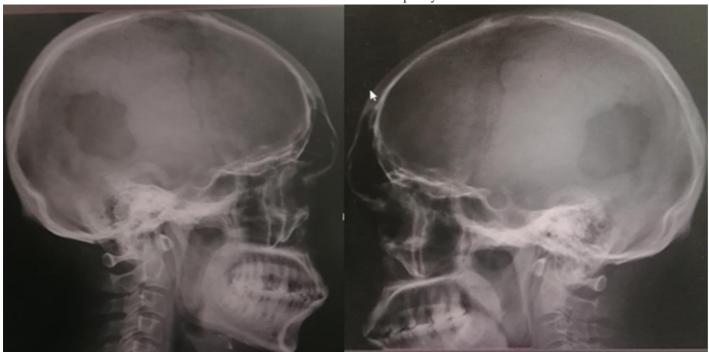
Skull X-ray showing Lytic lesions
